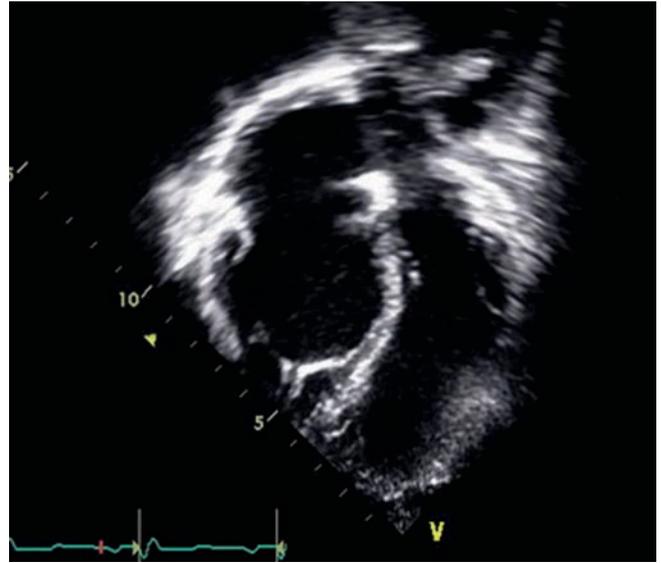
Ebstein's anomaly. Apical 4-chamber shows apical displacement of the septal leaflet
